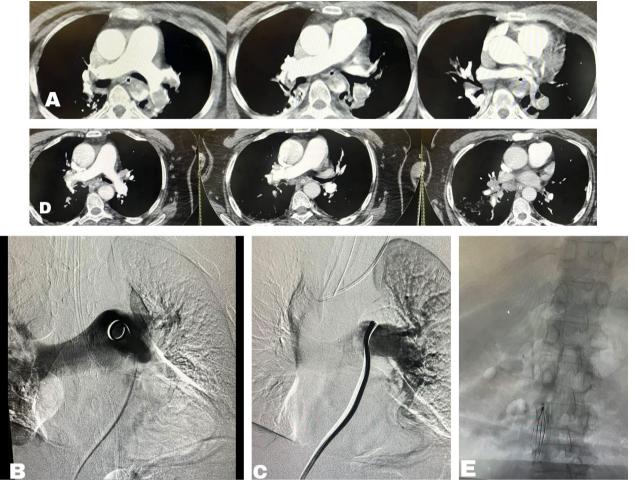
54 year old patient. Result of thrombectomy in patient with occlusion of left pulmonary arteries: A initial contrast CT image: occlusion of the left inferior lobar arteries confirmed by angiography (B), C after thrombectomy of the inferior lobar arteries of the left lung shows recanalization in the angiograppy image and in follow-up contrast CT (D), E IVC filter are inserted
